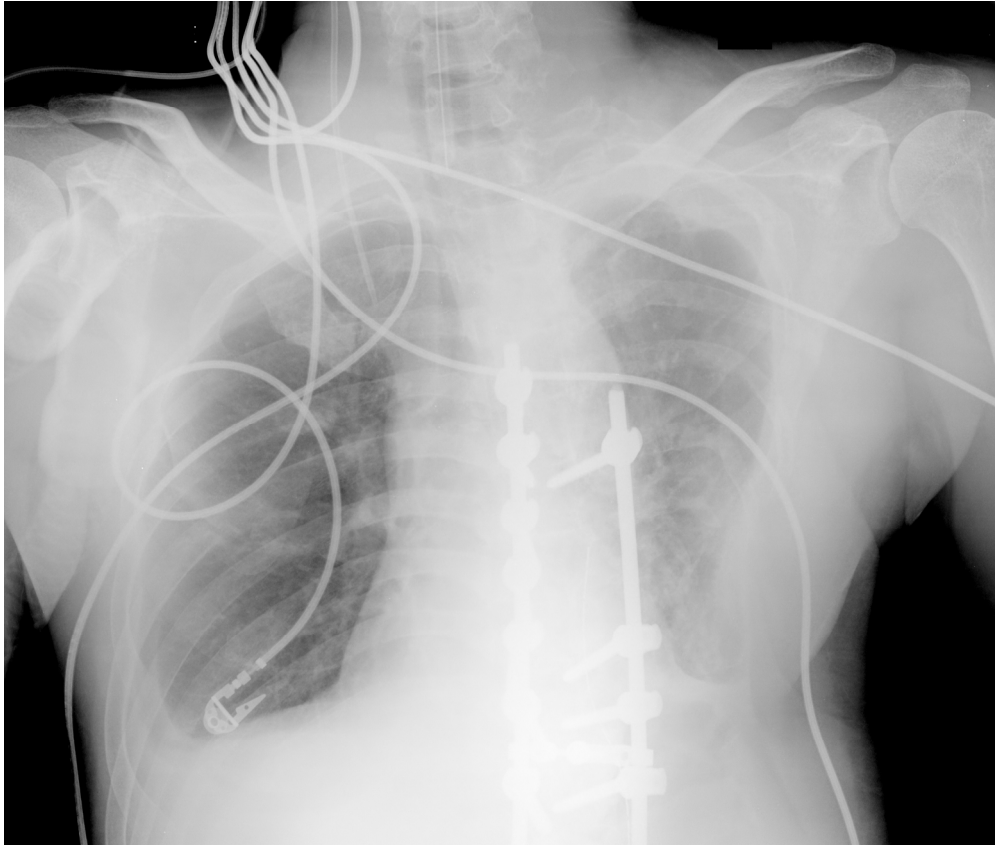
Chest x-ray after the first attempt at extubation (day 6 post-operation) showed left lower lung pneumonia with bilateral pleural effusion, and left lower ribs deformity. The endotracheal tube was in proper position.
